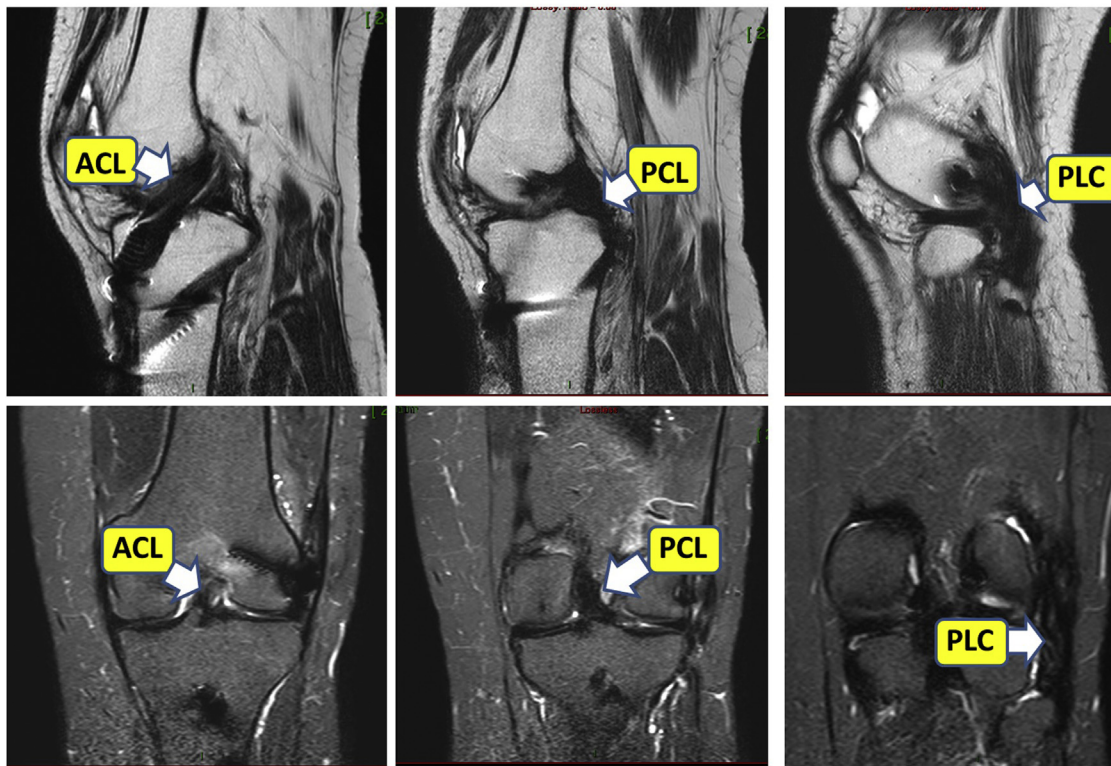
One-year postoperative magnetic resonance imaging of the left knee showing low signal well-aligned reconstructed ligaments including ACL (left-sided upper image sagittal view and left-sided lower image coronal view), PCL (central upper image sagittal view and central lower image coronal view), and PLC (right-sided upper image sagittal view and right-sided lower image coronal view). (ACL, anterior cruciate ligament; PCL, posterior cruciate ligament; PLC, posterolateral corner.)
